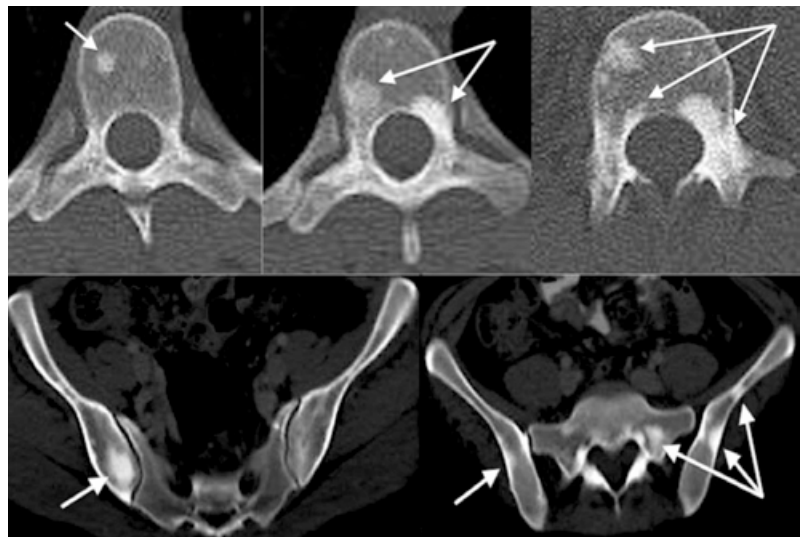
CT scans of the thoracic and lumbar vertebrae and pelvic bones showing multiple foci of dense bone tissue (arrows).
